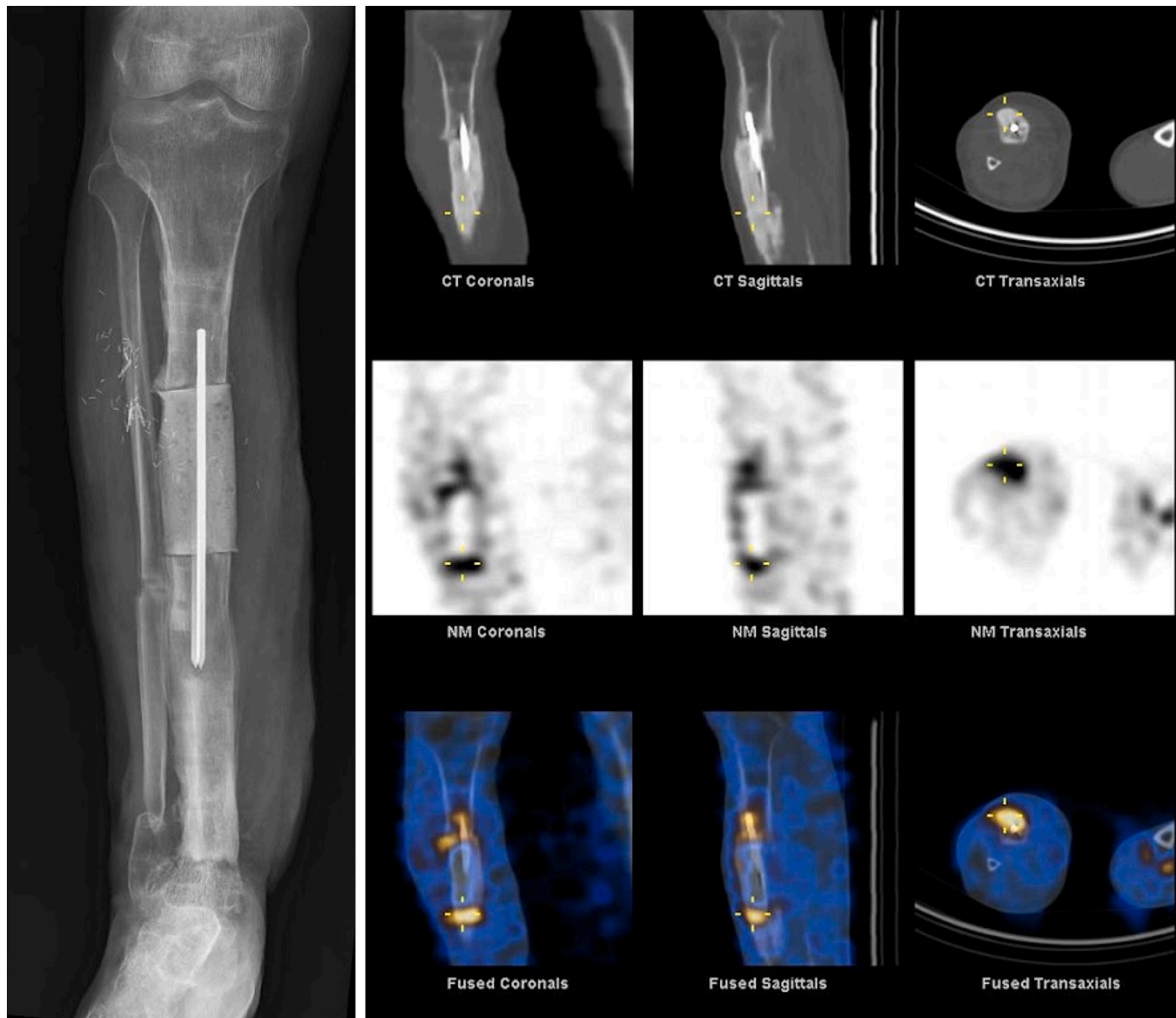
SPECT-CT scan at 6 weeks from the first surgery showing signs of normality.
